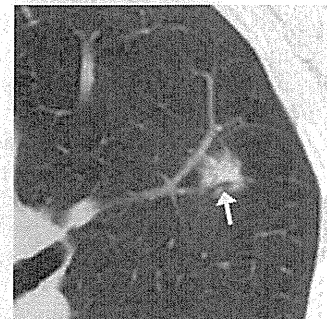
CT of mucinous adenocarcinoma in situ; 2 cm predominantly solid nodule with air bronchogram (arrow) is noted in the left upper lobe. CT, computed tomography.
